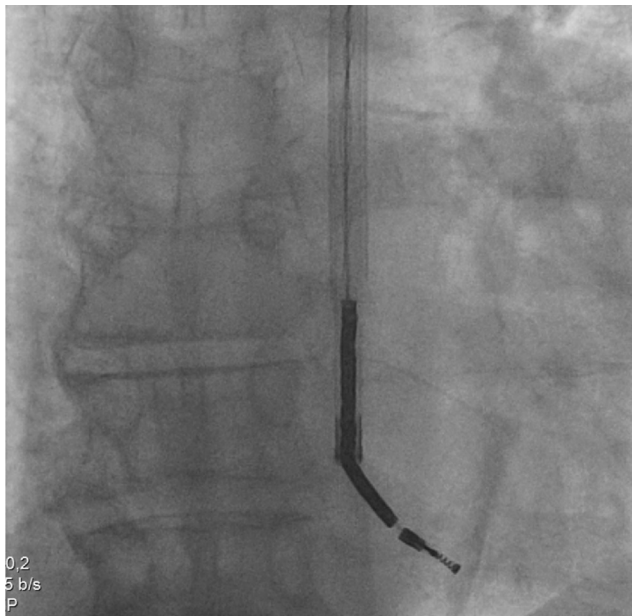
Radiography showing the 13F mechanical dilator sheath during transvenous extraction of the defibrillator lead.
